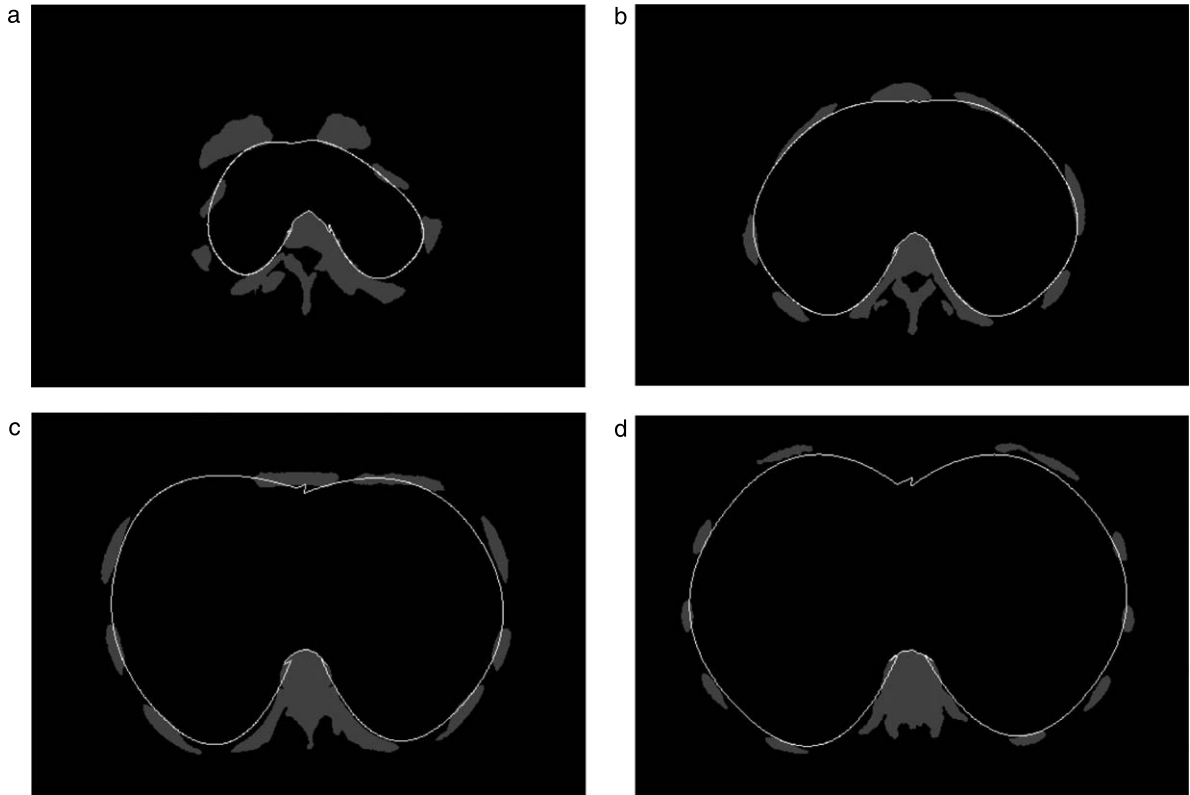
The inner wall chest boundaries in different CT scans.
